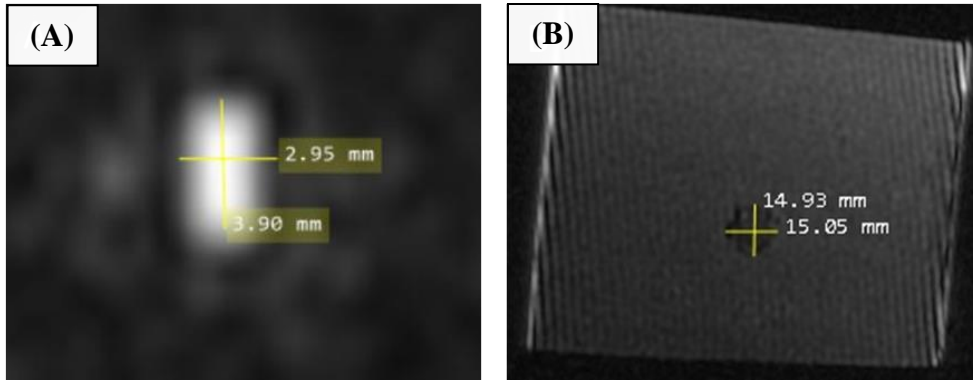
(A) Syringe and (B) tumour dimensions measured on the MRI image.
